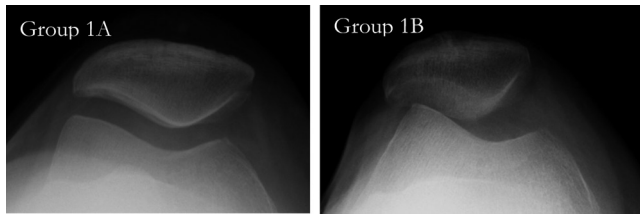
Distinguishing between medial TF OA knee with and without PLS by Merchant's view radiography.
